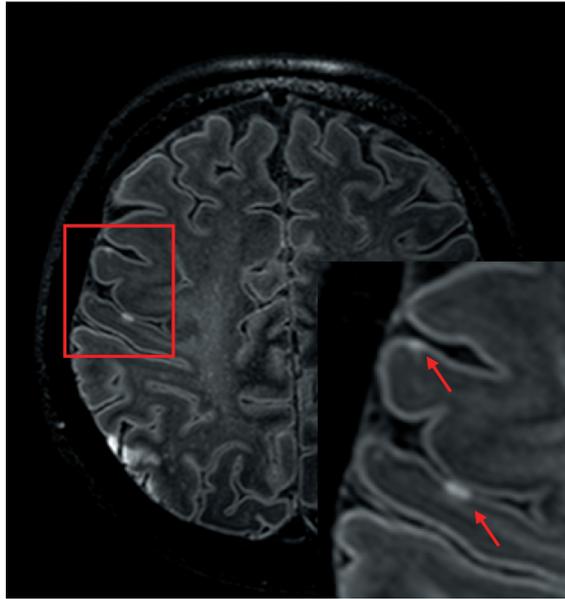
Example of minute acute cortical ischemic lesions on 7 Tesla FLAIR images (Brundel et al, 2012)
